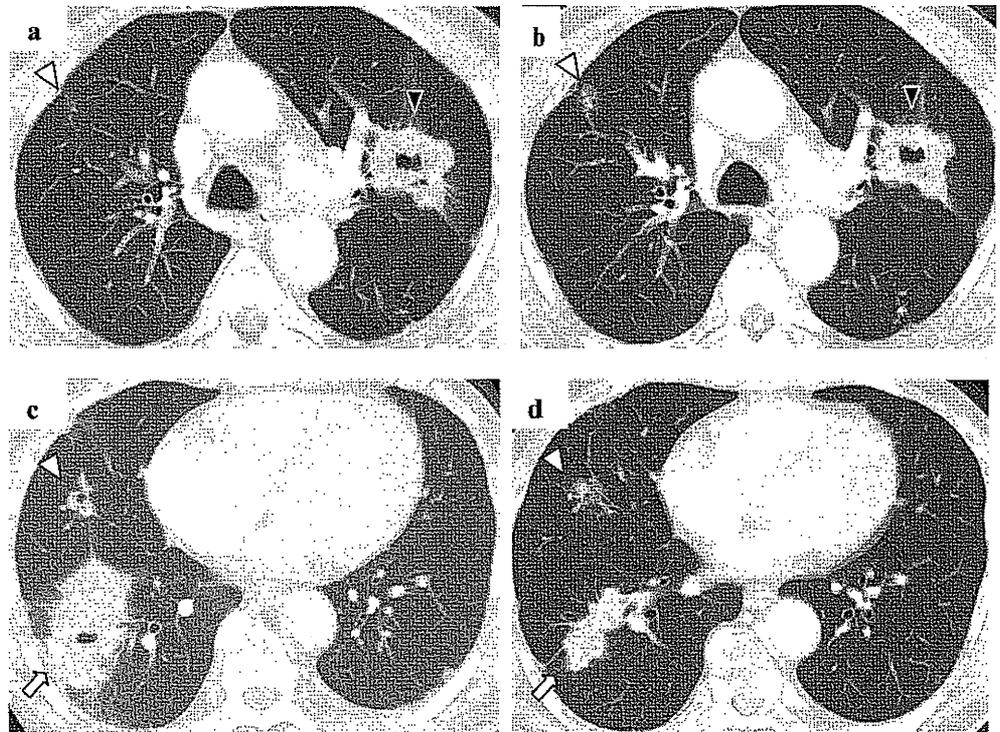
a Chest X-ray before initiation of cetuximab combination therapy. b Two months after therapy. *Arrow* indicates a responding tumor; *black arrowhead* indicates a slightly responding tumor; *white arrowhead* indicates a slightly enlarging nodule
